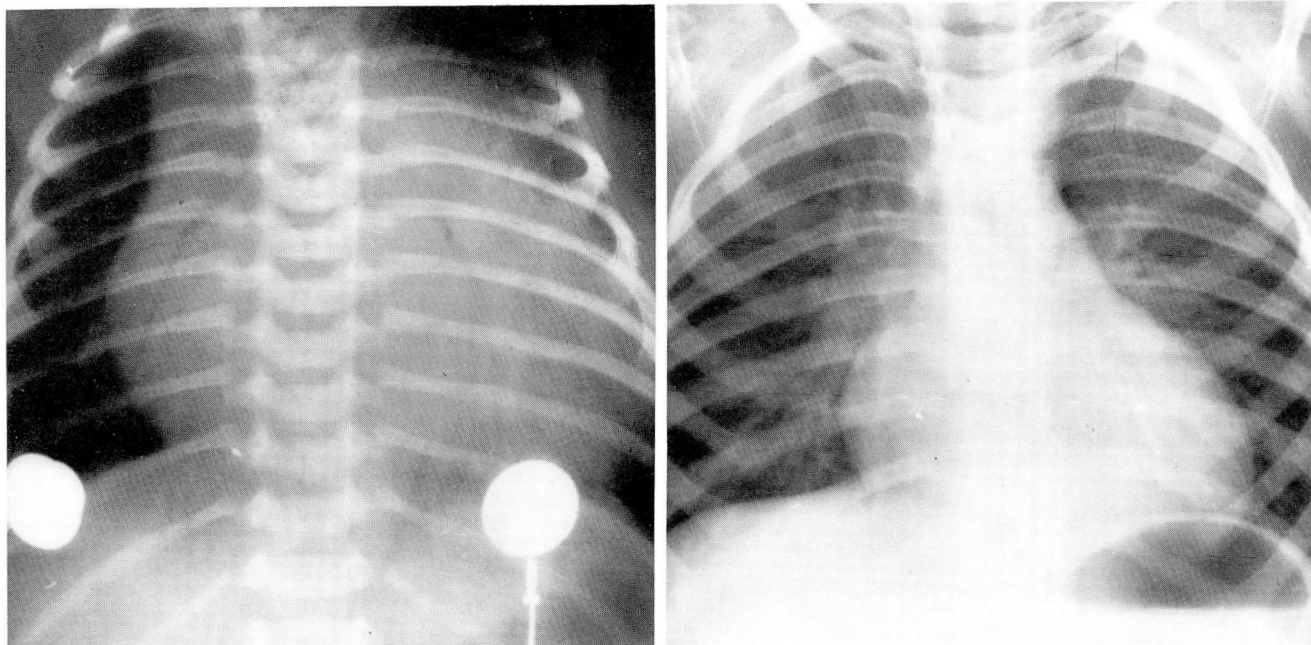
A. Case 1. Chest radiograph, anteroposterior view prior to surgical clipping, shows marked cardiomegaly. B. Anteroposterior view, three years after neurosurgical clipping. Heart size and pulmonary vasculature are normal.
